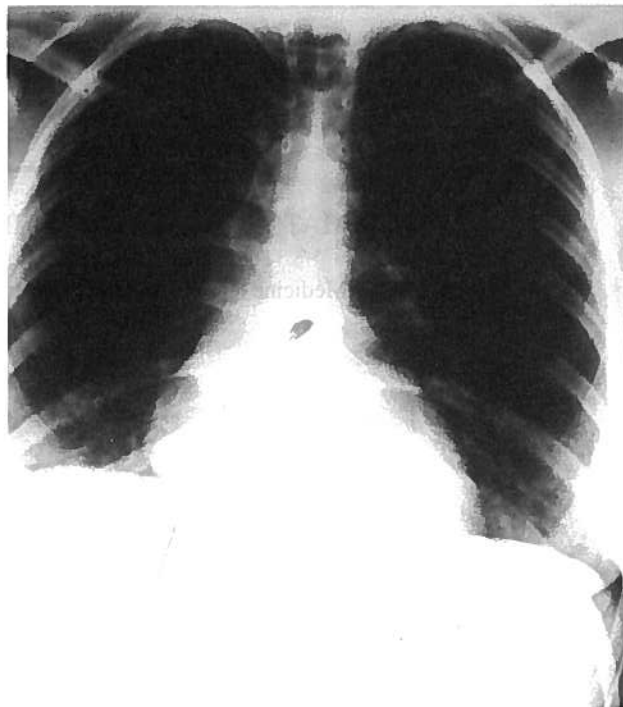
Chest X-ray: cardiomegaly, dilatation of pulmonary artery and the right lower border of cardiac silhouette.
